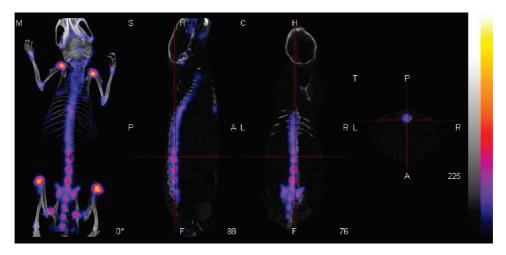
SPECT (color)/CT (grayscale) image taken 24 h postinjection showing the high uptake of 3 in bone tissue, particularly at the joints. From left to right, maximum intensity projection (M), sagittal (S), coronal (C), and transverse (T) sections.
